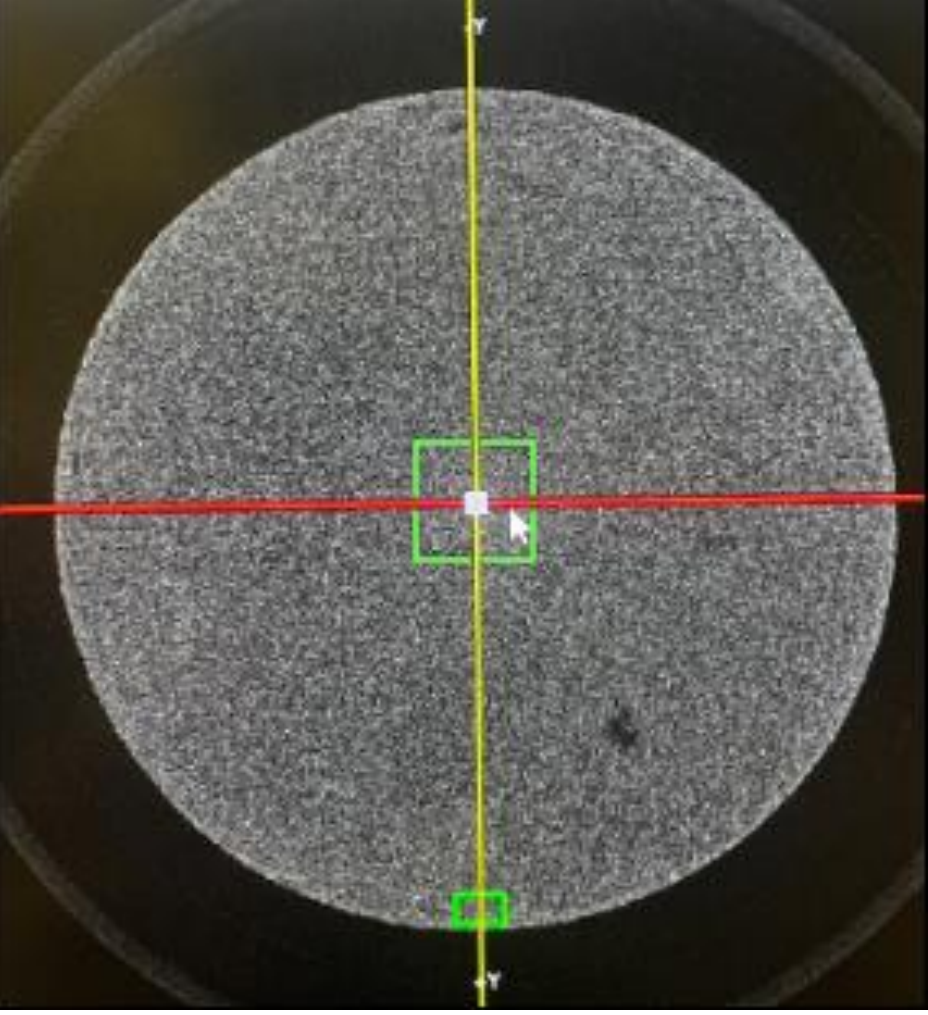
Representative micro-computed tomographic section of a cured disc, showing the two regions of interest. The central square (5 × 5 mm) defines the center region and the peripheral rectangle (2 × 1 mm) the surface region.
